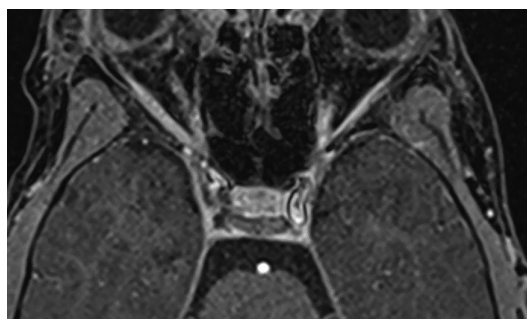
Post-gadolinium T1-weighted axial image showing a right-sided cavernous sinus thrombosis noticeable by the multiple T1 hypointense foci in the cavernous sinus as well as periorbital cellulitis with limited post-septal expansion.
